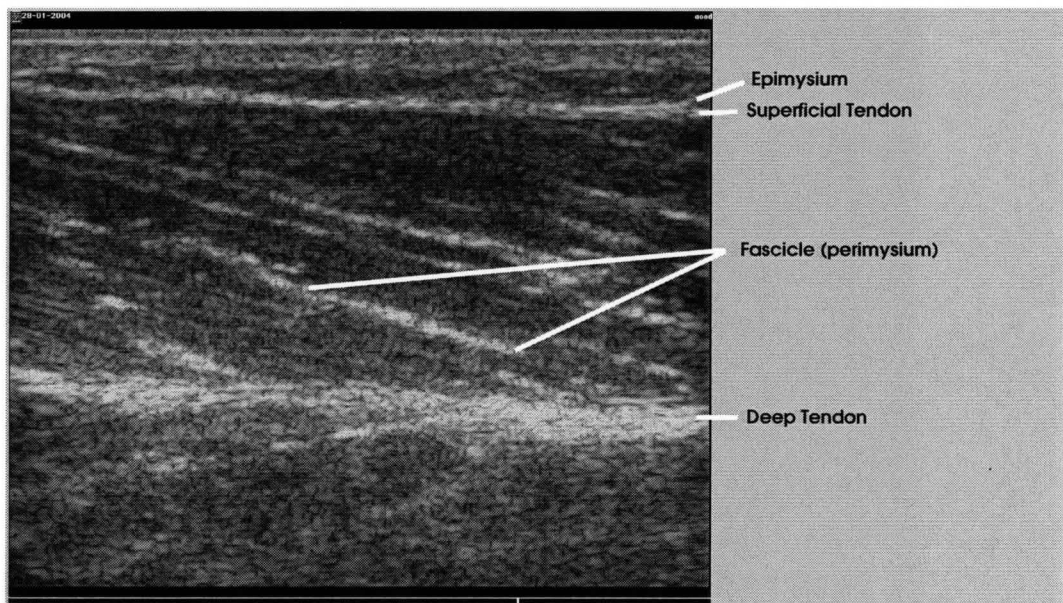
An ultrasound image showing specific visualized structures
